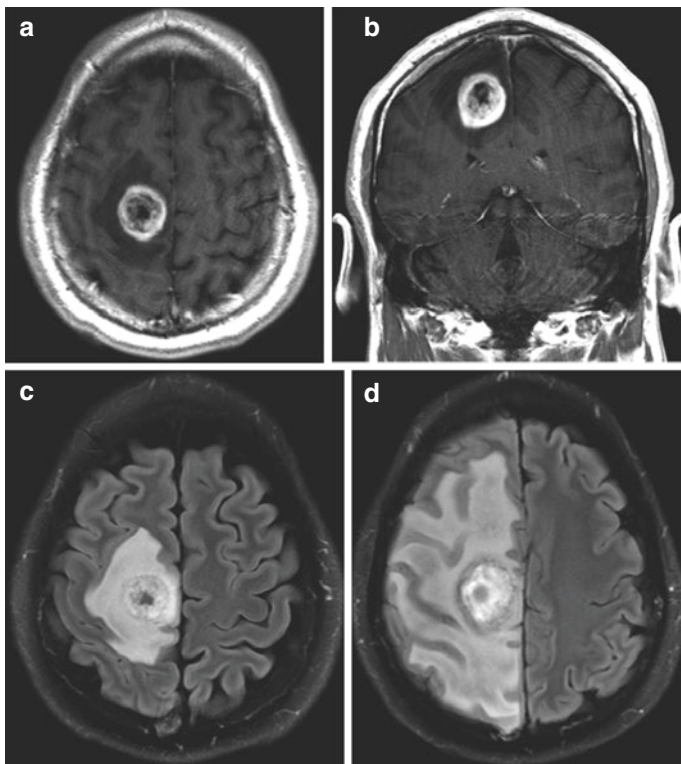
Case 1 Imaging. (a, b) Pretreatment axial and coronal T1 post-contrast MRIs demonstrate a ring-enhancing intra-axial mass with central necrosis. (c) Pretreatment axial FLAIR MRI demonstrates surrounding vasogenic edema that was managed with corticosteroids. (d) Posttreatment axial FLAIR MRI demonstrates a significant increase in vasogenic edema, which is now diffuse and encompasses the majority of the right cerebral hemisphere
